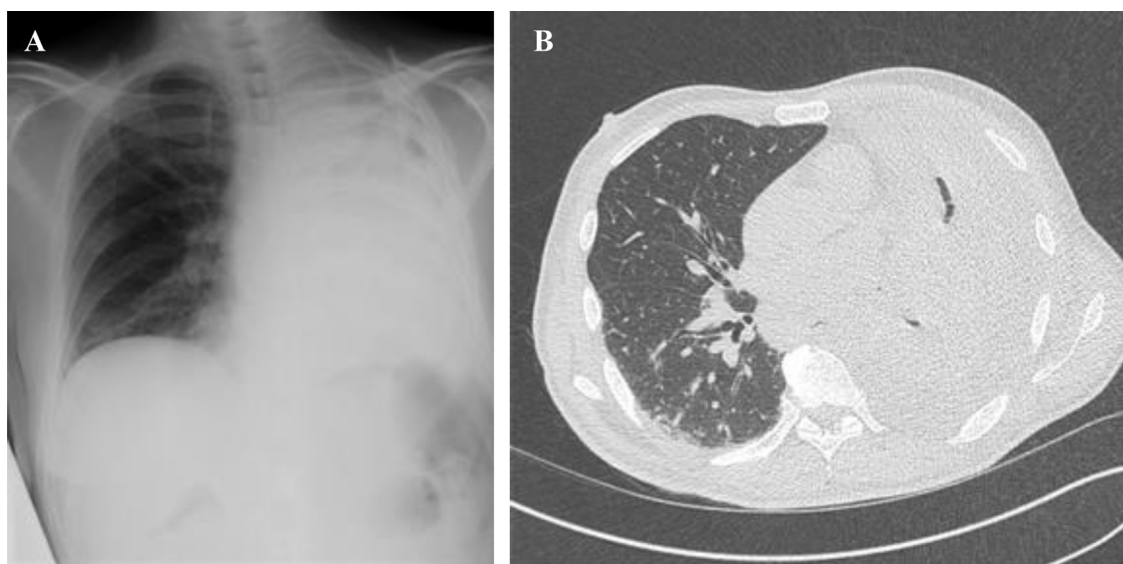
A: Frontal Chest X-ray: left lung atelectasis and suspicion of pleural effusion. B: Axial section of thoracic CT scan: left lung atelectasis with obstruction of left main bronchus and left pleural effusion.
